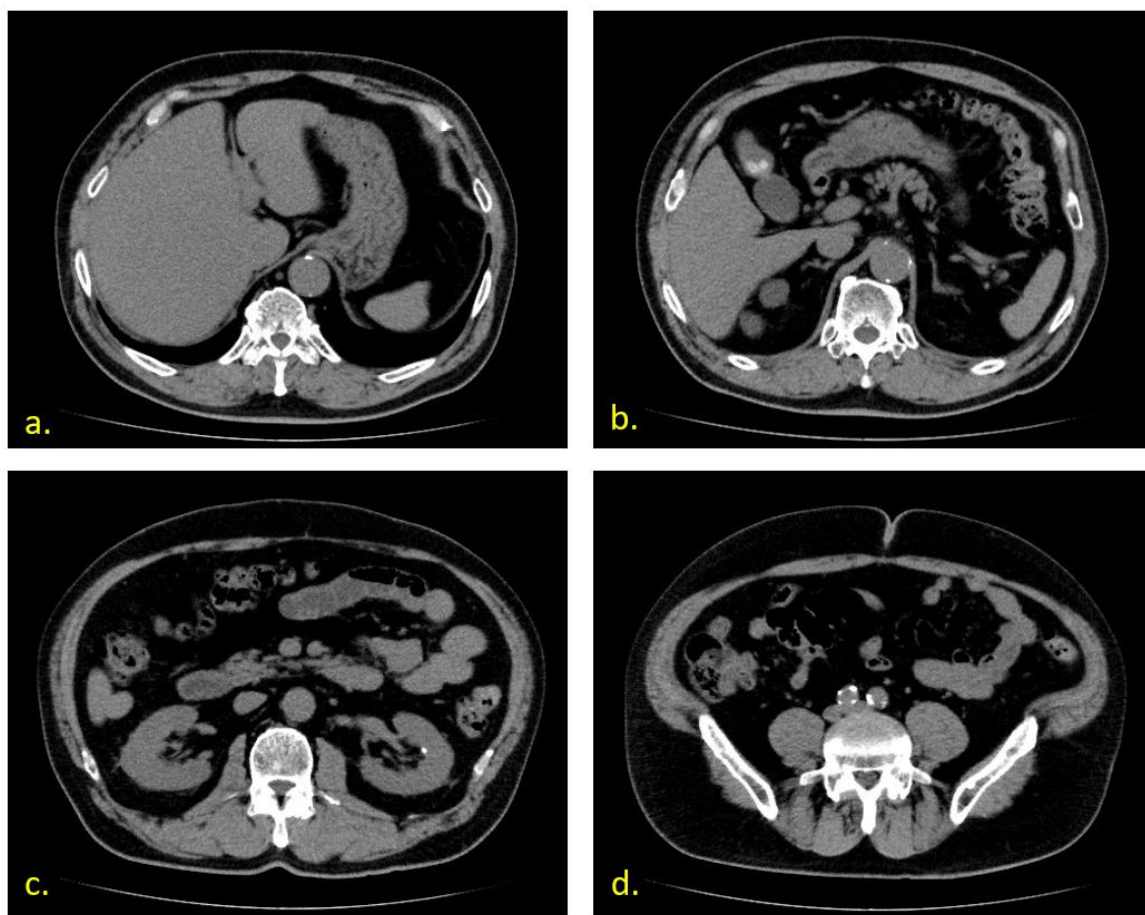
Abdominal CT Scan
